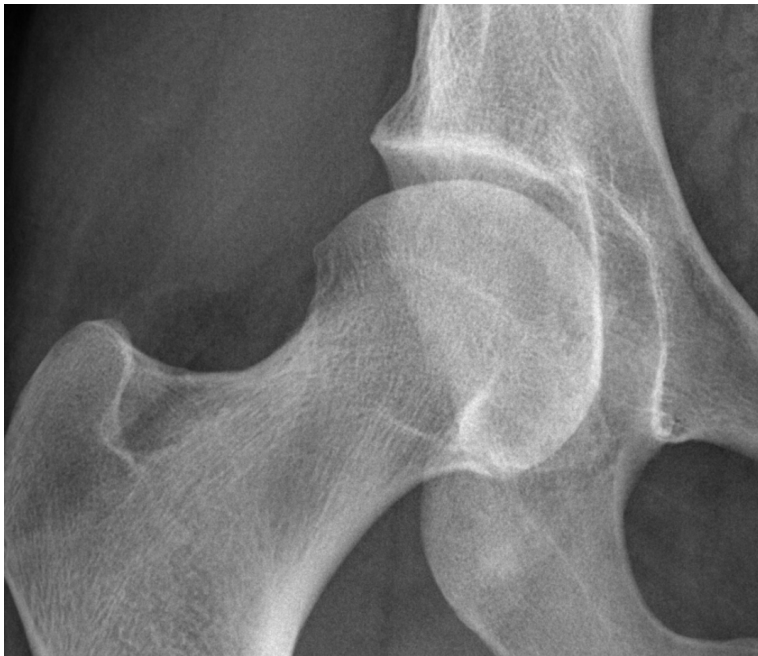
A small irregularity (possibly an osteophyte) on the lateral part of the femoral head was found in 5 hips (3 patients). Such hips did not differ from the rest with regards to radiographic measurements of DDH, minJSW or dGEMRIC index.
